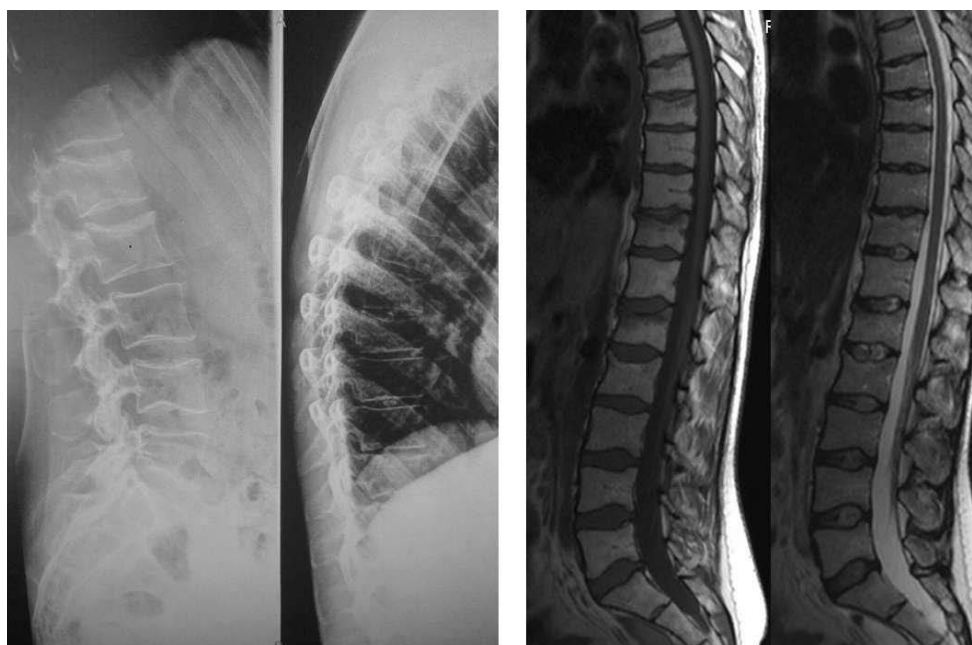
X-ray and T1- and T2-weighted MRI at diagnosis showing wedge compression fractures at T7, T8, T11, T12, L1, L2, L4, and L5 vertebral levels.
